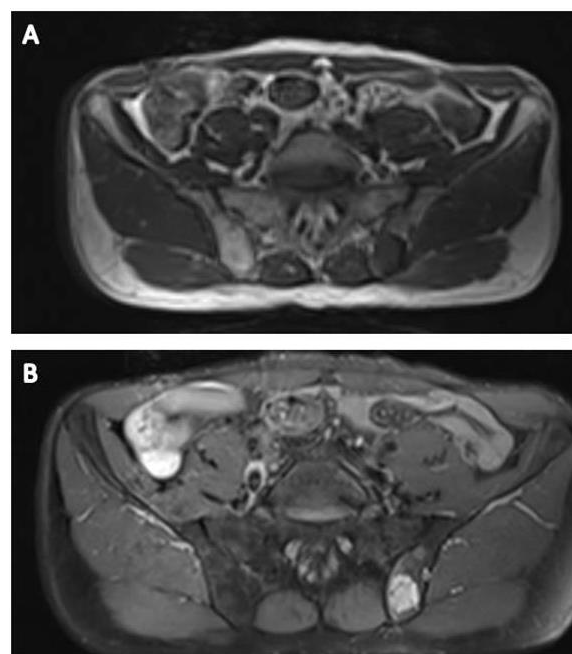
Pelvic transaxial MRI showed a low T1 weighted signal (A) and high T2 weighted signal (B) lesion in the left iliac ala next to the sacroiliac joint with adjacent bone marrow edema.
